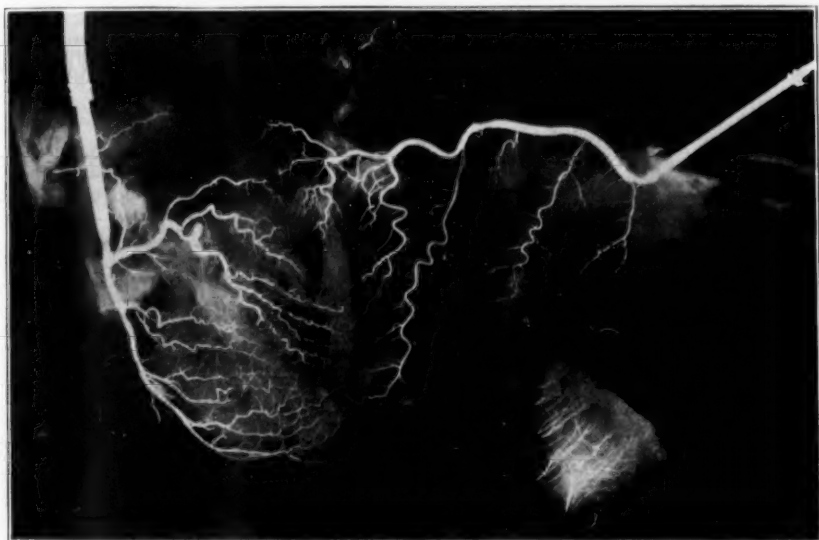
(case 2).—Roentgenogram of the injected heart.
